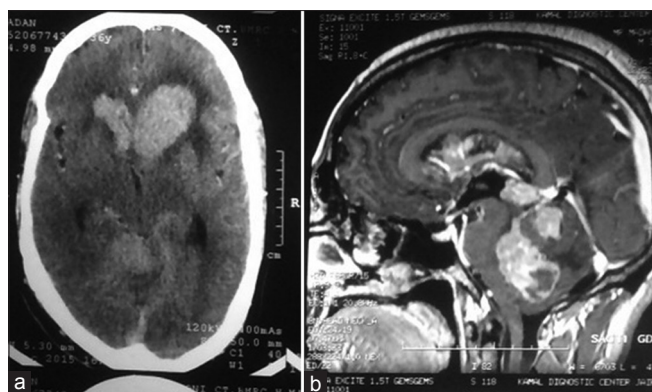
(a) Computed tomography scan showing multilobulated homogenous contrast-enhancing mass in lateral ventricles and fourth ventricle. (b) Magnetic resonance imaging showing multilobulated homogenous enhancing mass in lateral, third, and fourth ventricles
